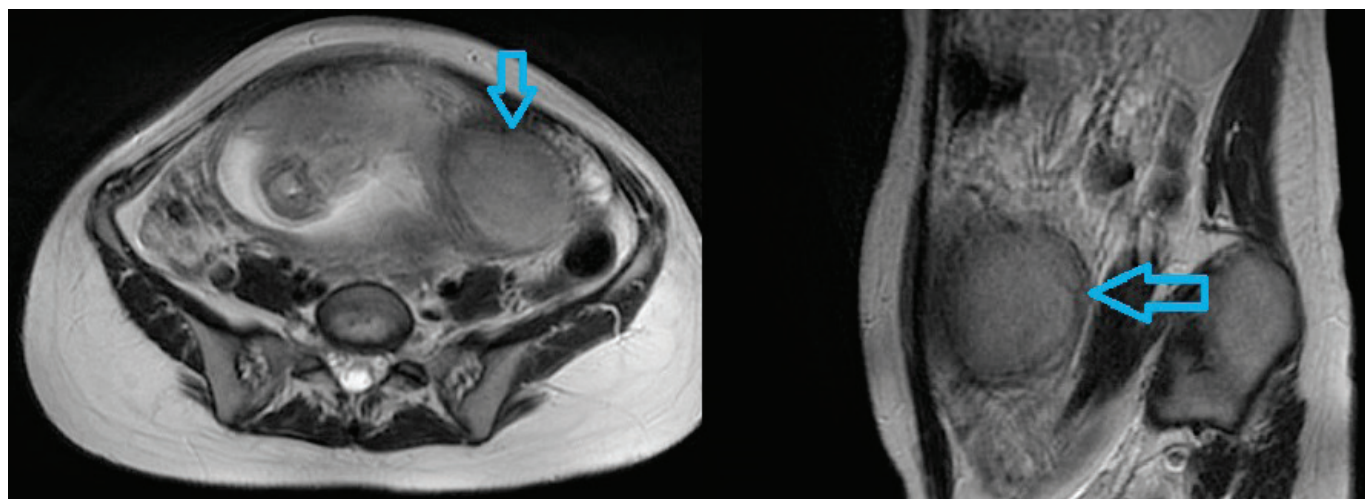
Two picture of pelvic MRI shows fibroma marked with blue arrows
